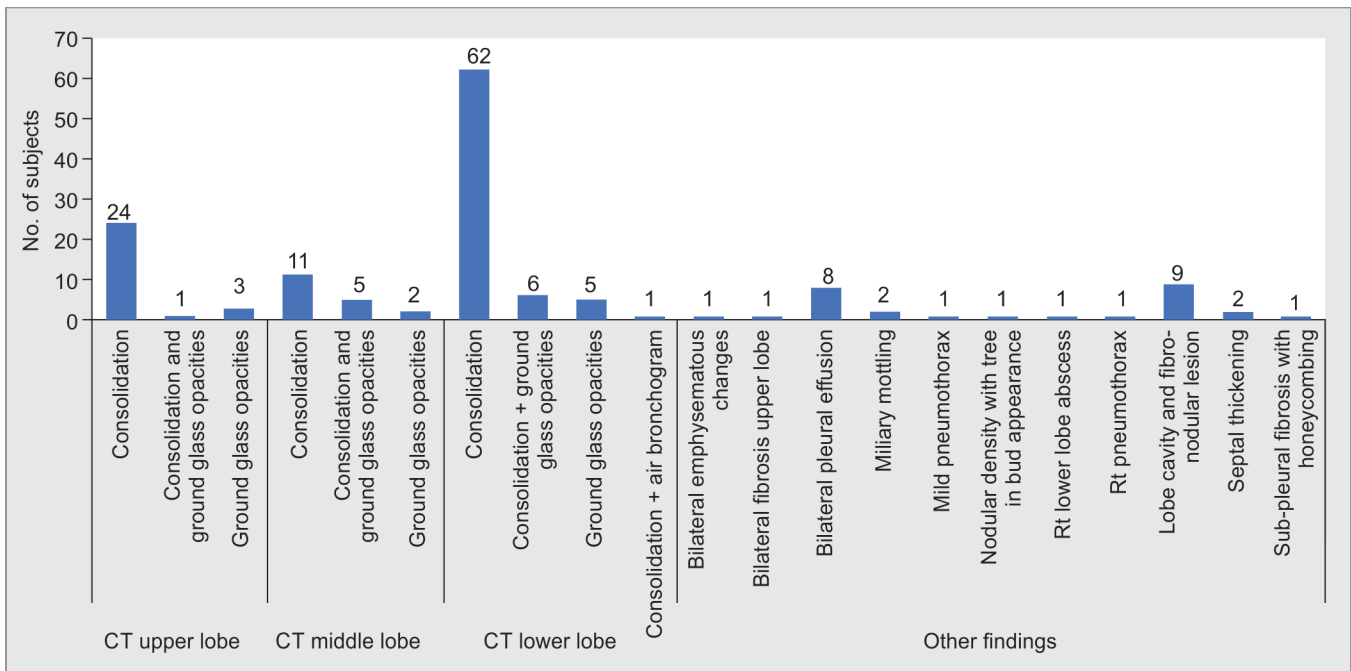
The CT-chest findings
